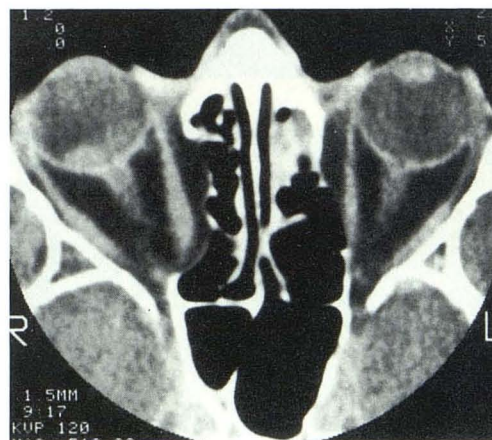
CT scan through level of mid-globes using a high-resolution 1.5-mm-thick axial section. Dislocated lens on right is seen as a high-density structure lying dependently against the retina. Lens on left is in normal position.
